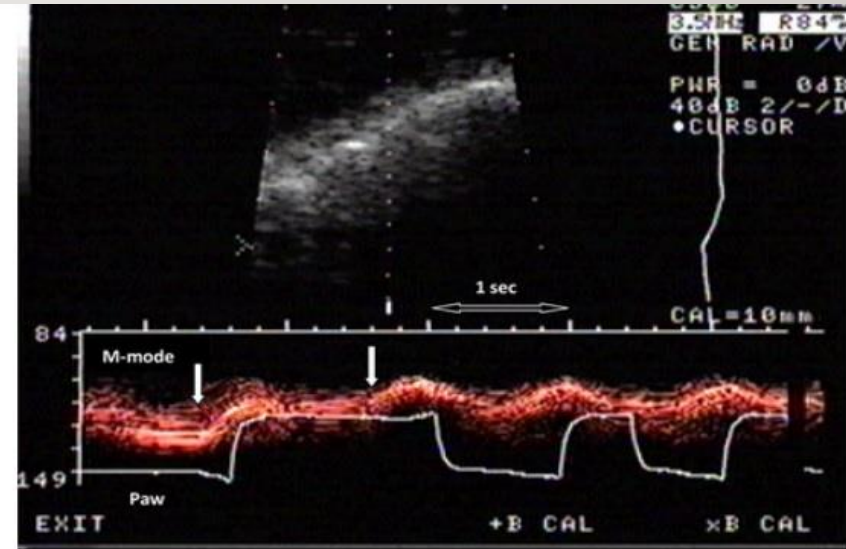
Diaphragmatic contraction in M-mode sonography and Paw in a COPD patient under pressure support ventilation, indicating patient-ventilator asynchrony. In the first assisted breath, ventilator inspiratory time is much longer compared to the second breath. In the first assisted breath, we notice two diaphragmatic contractions (arrows); the second diaphragmatic contraction prolongs the inspiratory time of the assisted breath
